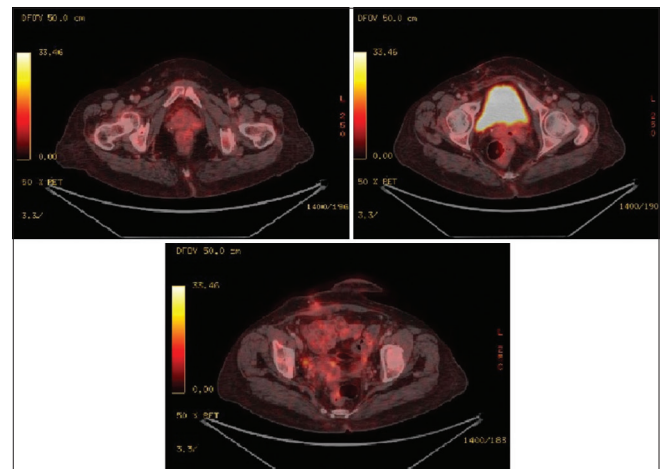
Postoperative positron emission tomography, computed tomography scan showing no residual or recurrence lesion
